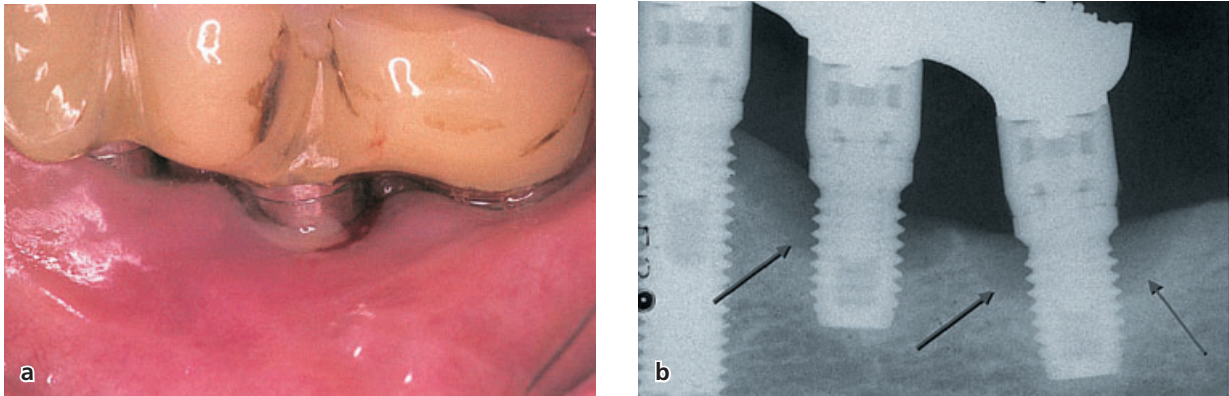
Clinical (a) and radiographic (b) characteristics of two implant sites with peri-implantitis in the left side of the mandible. Note the presence of swelling and suppuration in the peri-implant mucosa (a) and the crater-formed bone destruction around the implants in the radiograph (arrows) (b).
